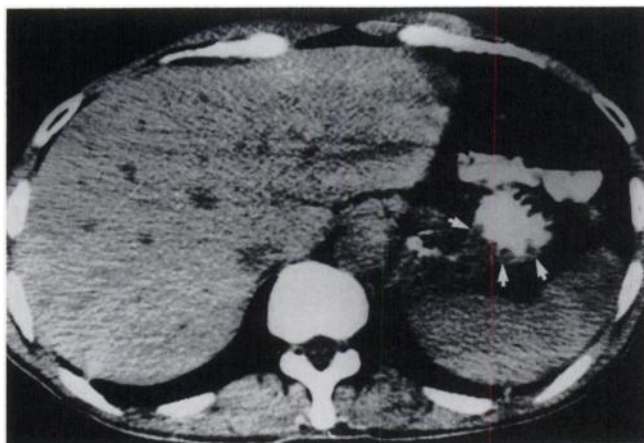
Abdominal CT scan identifies thickened mucosal folds (arrows) for the same patient shown in Figure 2.
